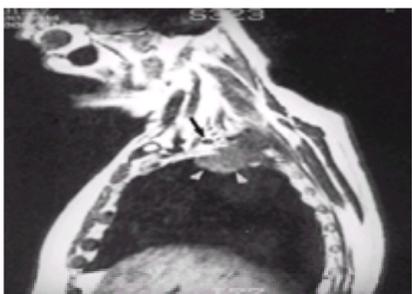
A superior sulcus neoplasm (*white arrowheads*) extending through the parietal pleura into the supraclavicular fossa is depicted on a sagittal MRI. The cancer spares the subclavian artery (*black arrow*) and brachial plexus, immediately cephalad to the artery.
